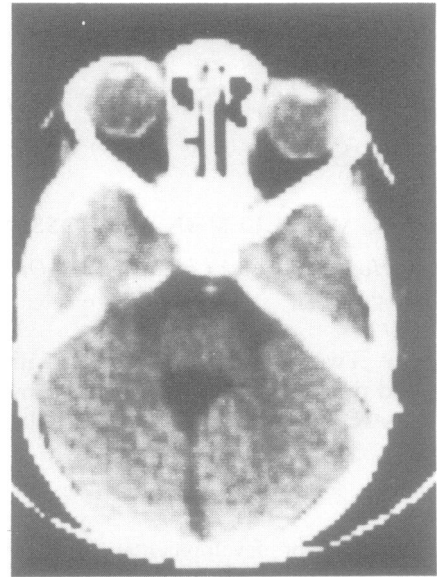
Case 2: CT showing an enlarged fourth ventricle communicating with cisterna magna.
